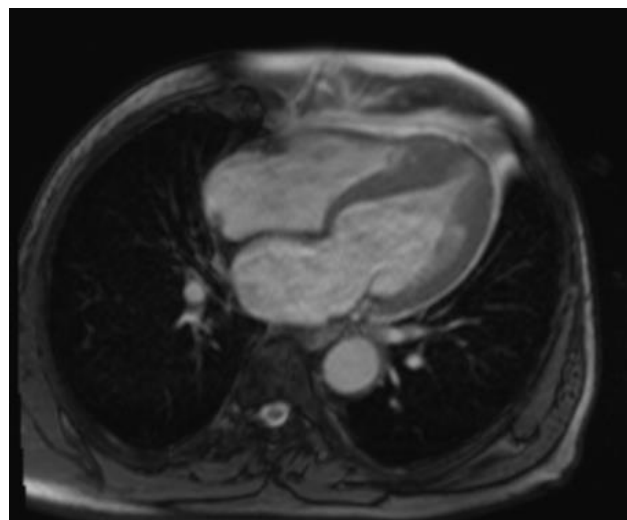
Magnetic resonance imaging of Yamaguchi syndrome
